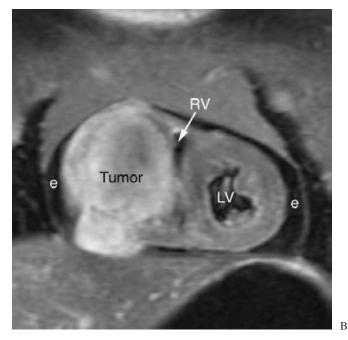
Fibroma involving the right ventricular free wall. A. T1weighted MR image in coronal plane shows a large tumor involving the free wall of the right ventricle (RV). The signal intensity of the tumor is similar to that of myocardium but a little heterogeneous. B. Contrast-enhanced T1-weighted MR image with fat saturation shows heterogeneous enhancement of the tumor. e, pericardial effusion; LV, left ventricle.
